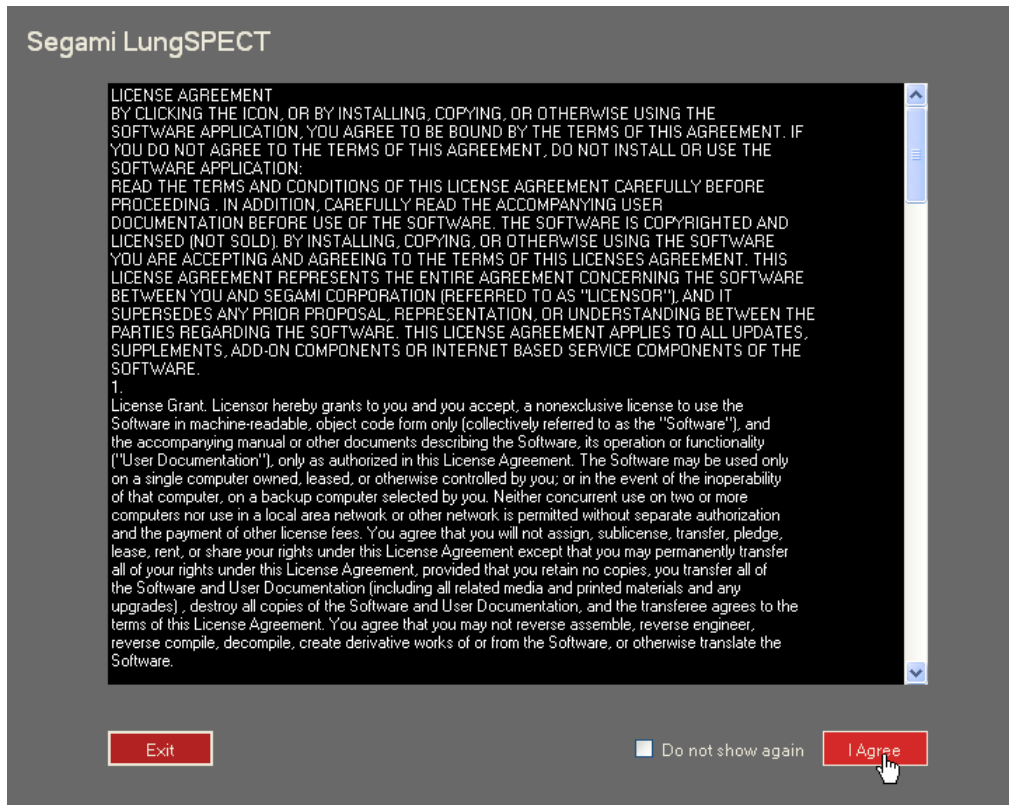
The Segami LungSPECT license agreement dialog.
